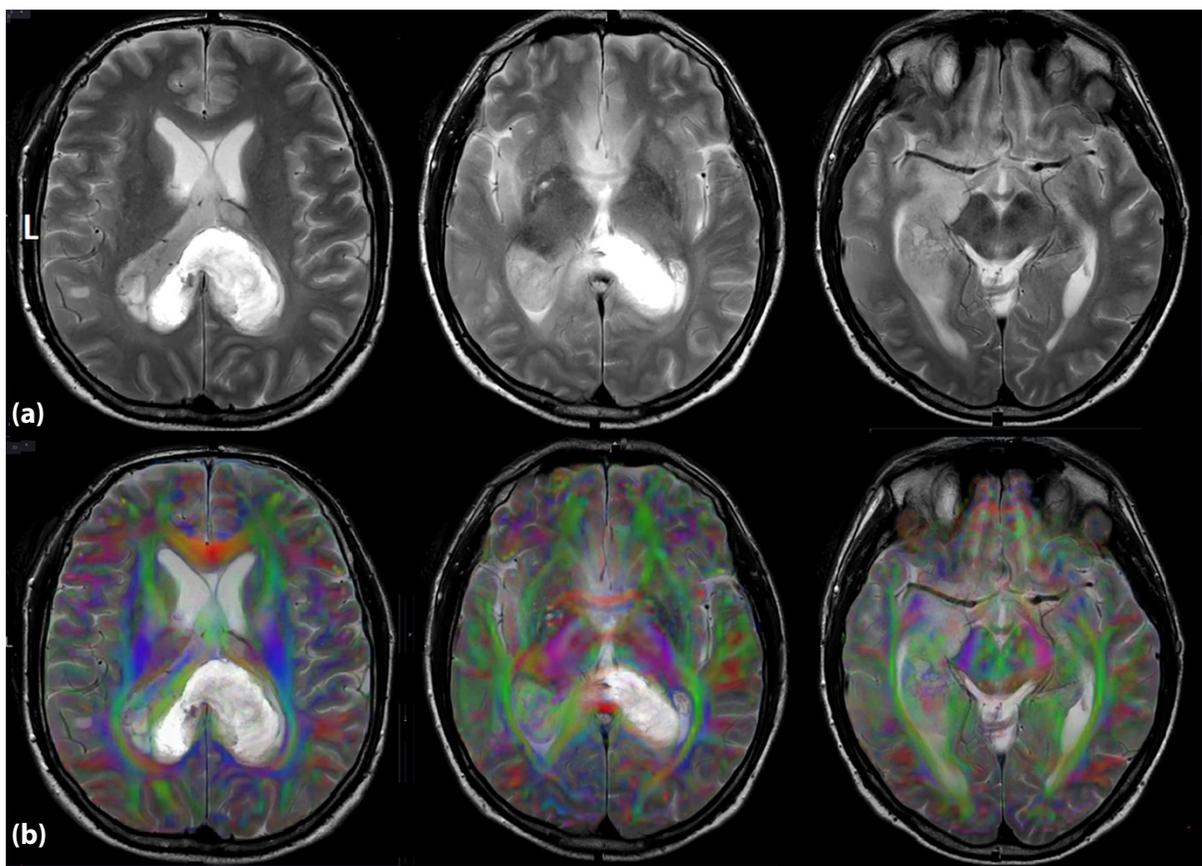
Consecutive axial T2-weighted images reveal an extensive lesion centered in the left anteromedial temporal lobe, involving the mesial temporal structures, limbic pathways, and the splenium of the corpus callosum, with extension into the contralateral hemisphere. Additional cortico-subcortical involvement is observed in the left insular, parietal, and posterior temporal regions (a). Corresponding color-coded fractional anisotropy (FA) maps demonstrate displacement, deviation, and disruption of adjacent white matter tracts caused by the lesion (b).
